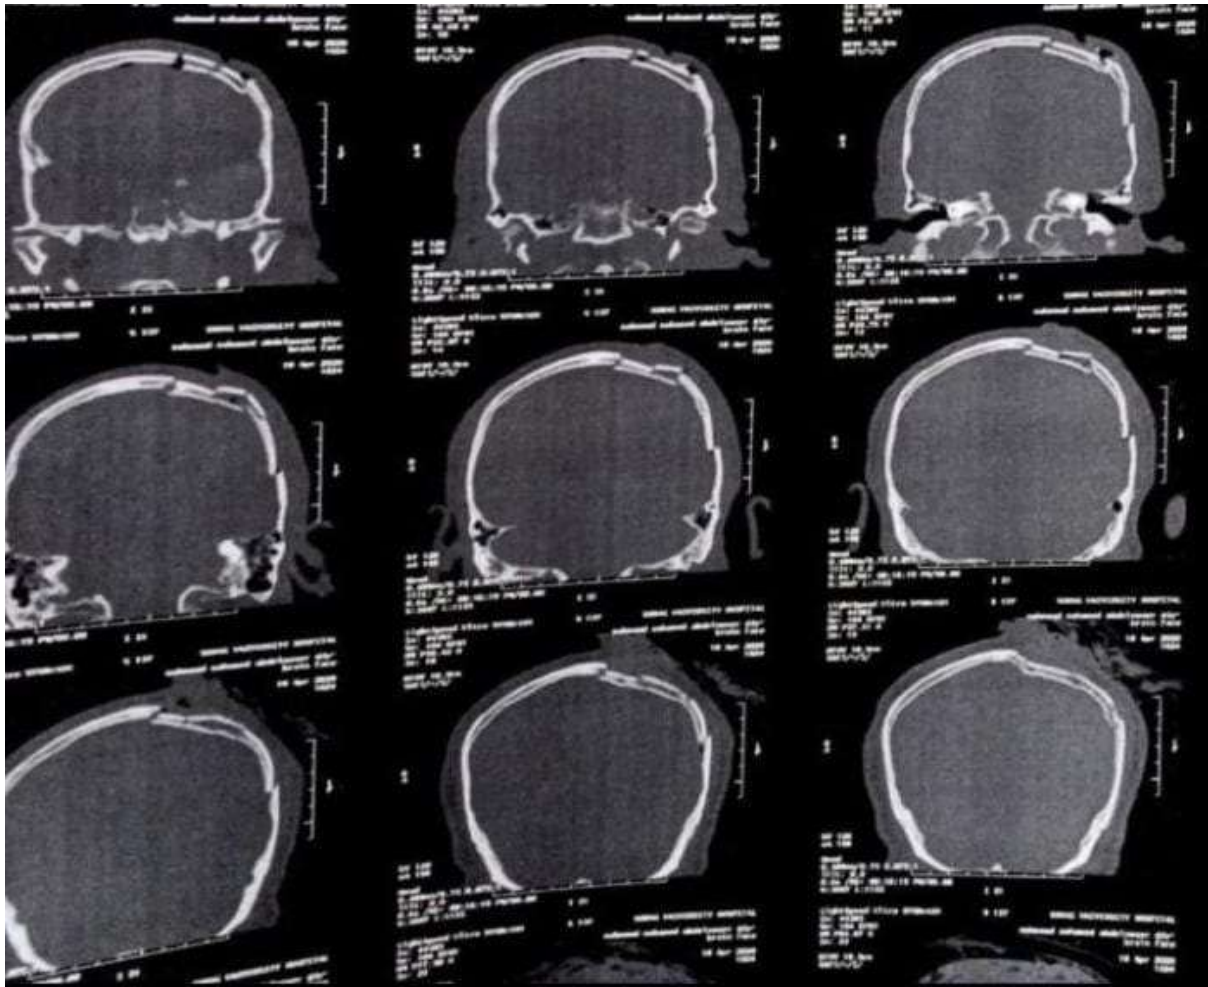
CT coronal cuts showing left parasagittal parietal depressed fracture
